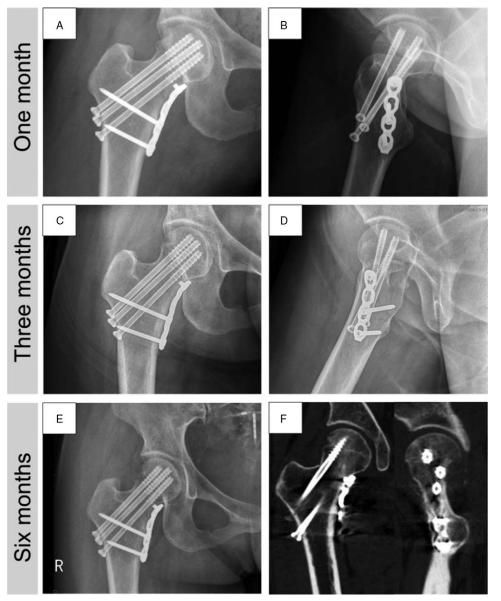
Postoperative x-ray examination and CT scanning of the positive and lateral positions of the femur at 1 month (A, B), 3 months (C, D), and 6 months (E, F). CT = computed tomography.
